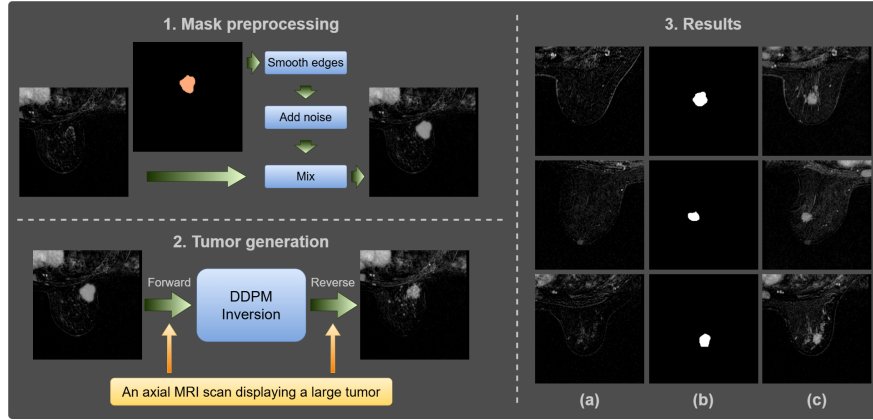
Tumor insertion into healthy breast MRIs using DDPM inversion. (1) Tumor mask insertion into a healthy breast image as a noisy mask, (2) Artificial mask transformation to realistic tumor via DDPM inversion, and (3) Example results: (a) real healthy breast MRI, (b) tumor mask, (c) generated image with a synthetic tumor.
